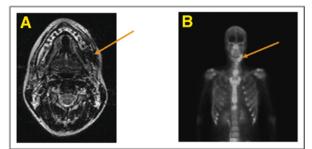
Advanced Osteonecrosis of the Jaw—This often shows lytic changes or "mottled bone" on MRI scans (A). Bone scan may reveal increased uptake in the area of osteonecrosis of the jaw (B).
